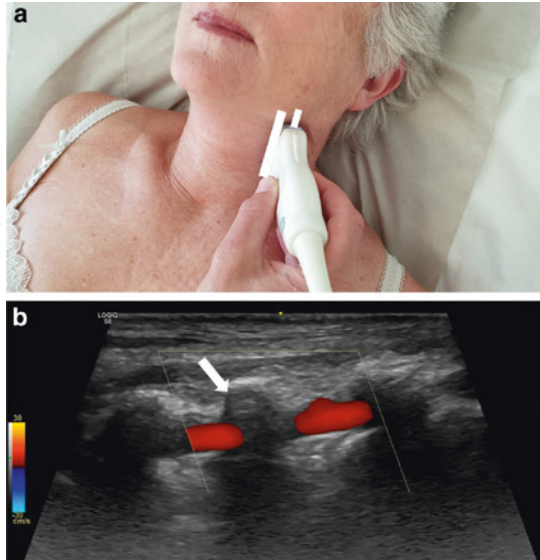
Examination of the vertebral artery: a recommended transducer position, b ultrasonographic view of the vertebral artery, passing through the vertebra (white arrow)
